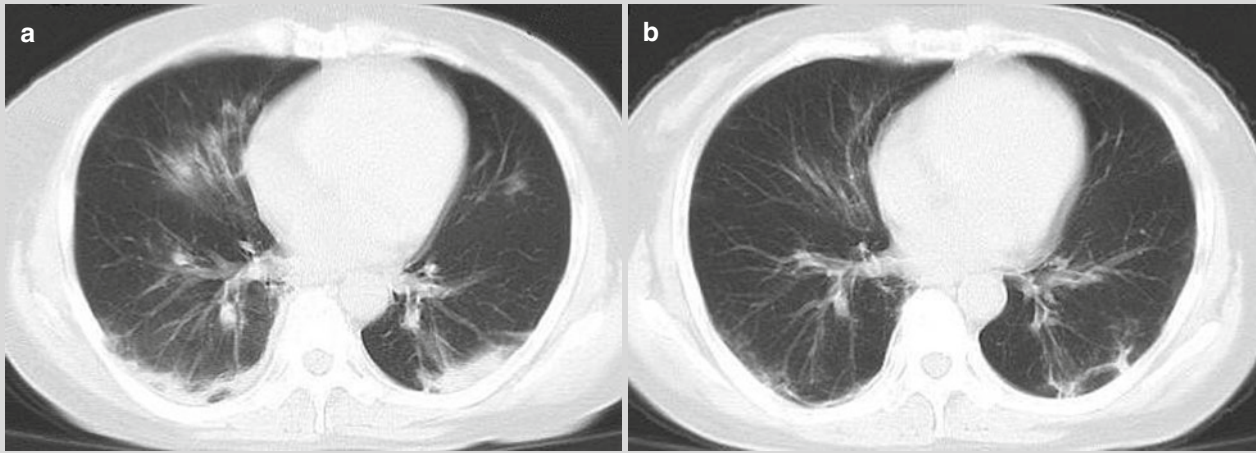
CT scan showed patchy and curved flake like opacity in the right middle lung lobe, lingular segment of the left lung, and subpleural areas in bilateral lower lung lobes, some of which were
